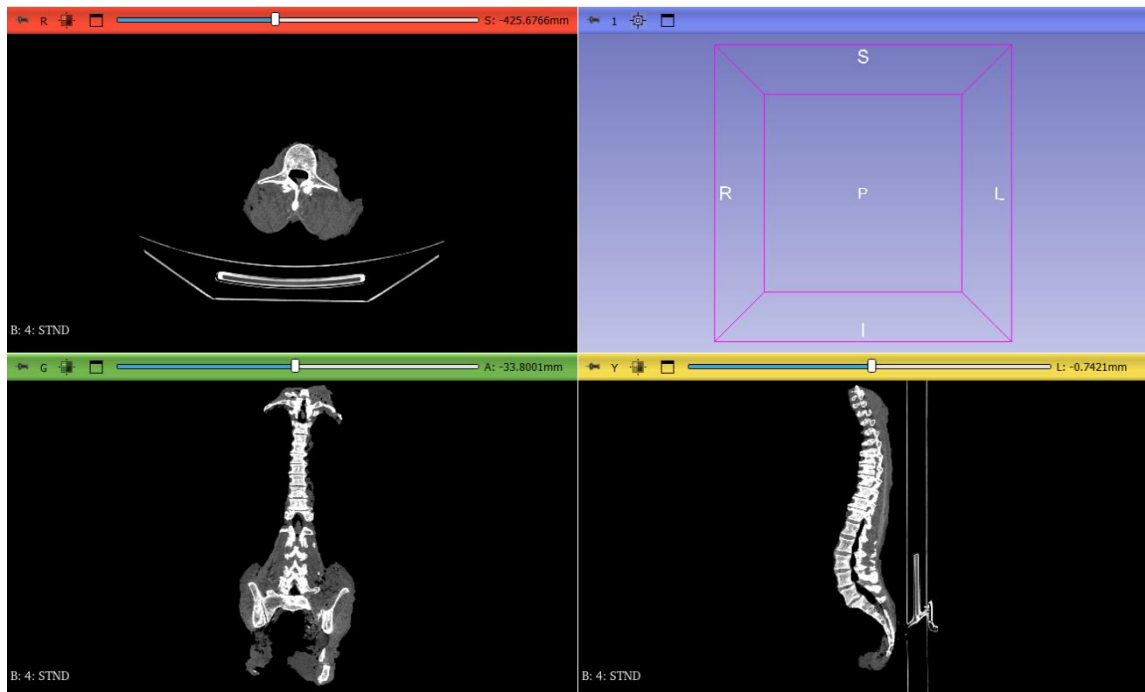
Importing CT images into the 3D Slicer environment
